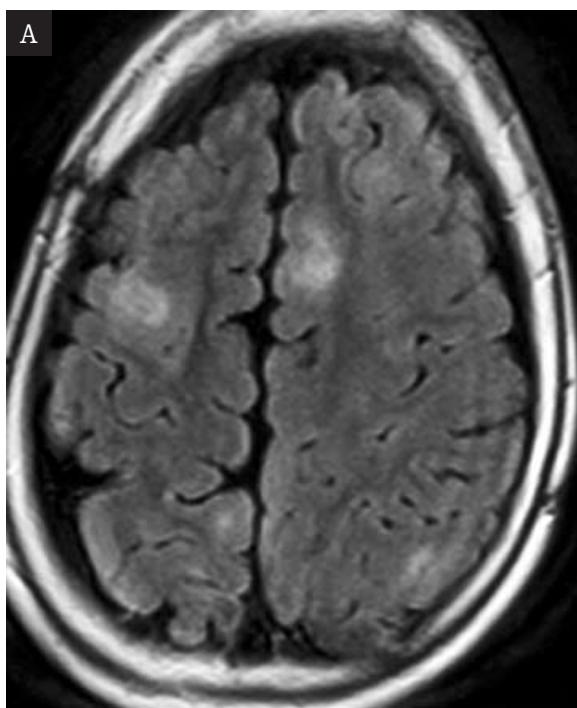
Cerebral cortical tubers. FLAIR sequence showed hyper- and hypointense lesions. A – axial image shows hyperintense signal of cortical tubers. B – axial and coronal images show hypointense signal of cortical tubers.
